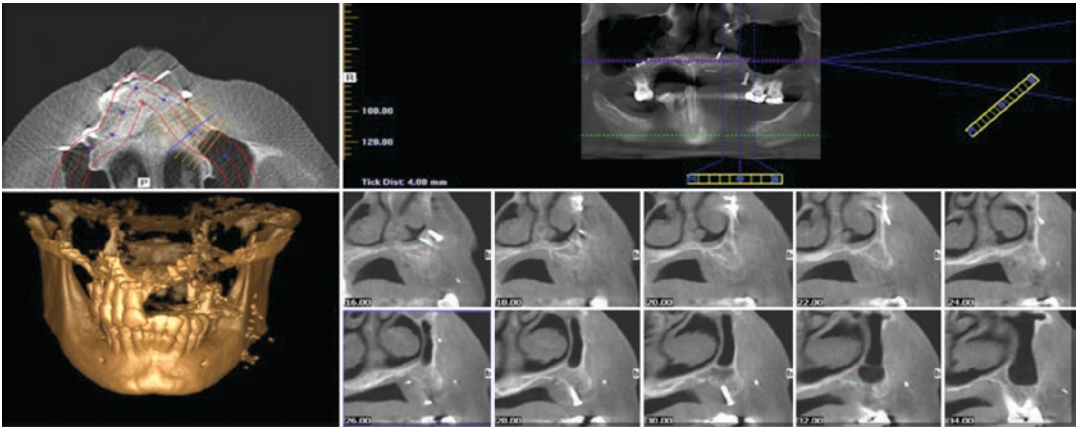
CBCT 5 months post-op imaging demonstrating consolidation and maturation of avascular bone graft underneath radial forearm flap
